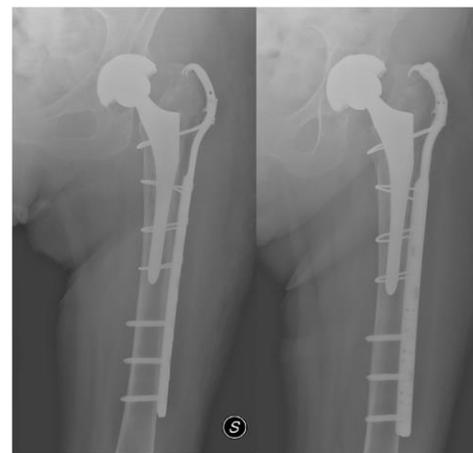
Vancouver B1 fracture: postoperative radiographs showing treatment with ORIF.
